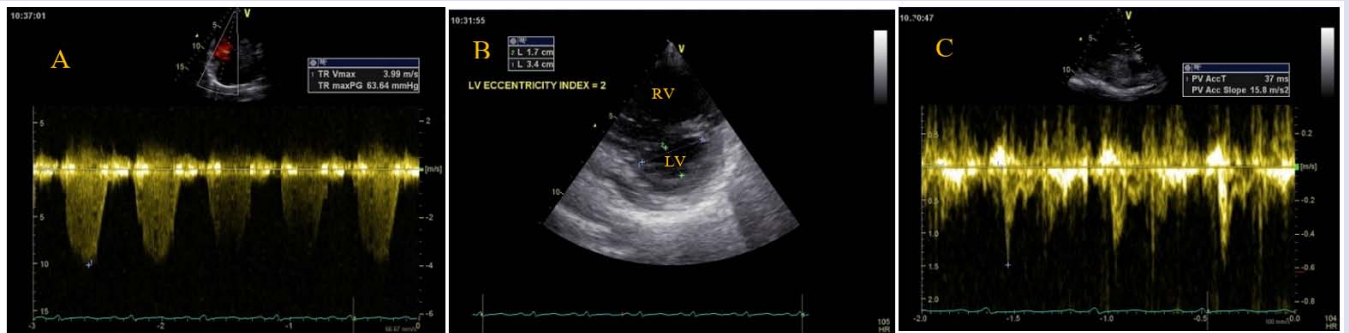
Parameters for assessing the probability of pulmonary hypertension on transthoracic echocardiography (A) Peak tricuspid regurgitation velocity (TR Vmax 3.99 m/s); (B) Left ventricle eccentricity index = 2; (C) Pulmonary acceleration time (PV AccT 37 ms).
